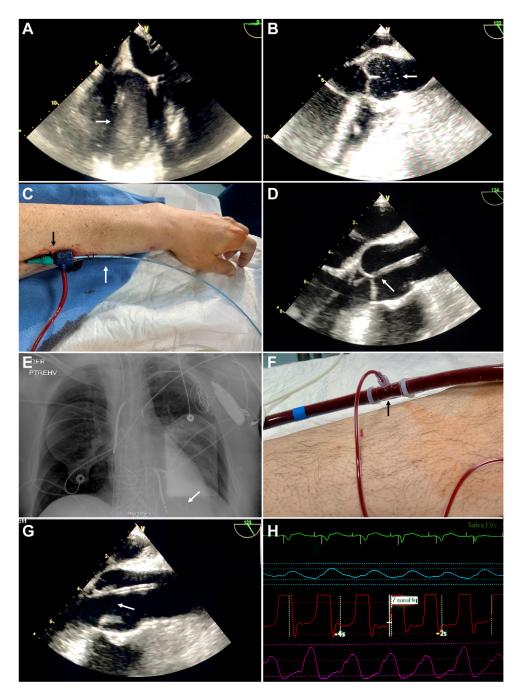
(A) Transesophageal echocardiography (TEE) 4-chamber view. Dilated left ventricle with spontaneous echo contrast (white arrow). (B) Absence of opening of the aortic valve and spontaneous echo contrast in the aortic root (white arrow). (C) Through a 6-French sheath introducer in the left radial artery (black arrow), a 6-French pigtail catheter is introduced to the left ventricular (LV) cavity (white arrow). (D) Real-time TEE guidance showing the catheter passage through the aortic valve (white arrow) into the LV cavity (3-chamber view). (E) Chest X-ray showing the tip of the catheter at the LV cavity (white arrow). (F) The pigtail catheter is connected directly to the extraction cannula (black arrow). (G) Real-time TEE showing the opening of the aortic valve (white arrow) after the drainage is initiated (3-chamber view). (H) LV end-diastolic pressure of 7 mm Hg is registered.
